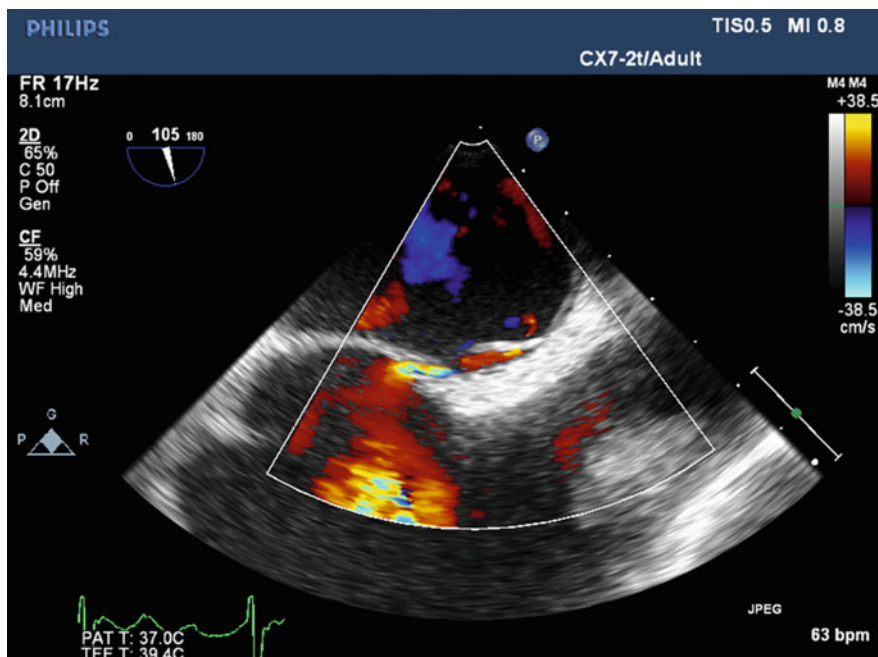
Midesophageal bicaval view in a patient with a patent foramen ovale and right-to-left flow on color flow Doppler
